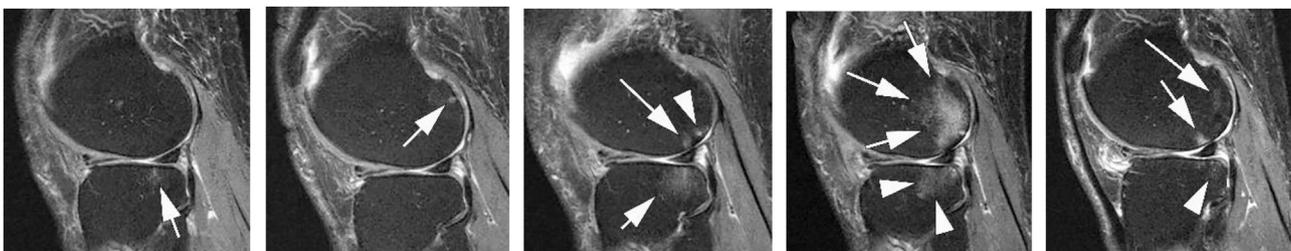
Example longitudinal assessment of bone marrow lesions (BML) in the lateral tibio-femoral compartment. BMLs are fluctuating features of OA that may show decrease in some subregions and increase in others over time. A. Baseline sagittal intermediate-weighted fat-suppressed MRI shows a grade 1 MOAKS BML in the posterior lateral tibia displaying high-signal intensity, comprised of an ill-defined (edema-like) component only (arrow). B. Follow-up MRI one year later shows complete resolution of tibial BML but a dot-like small new BML at the posterior lateral femur (arrow). C. Further follow-up 1-year later shows incidence of a large grade 3 BML at the posterior lateral tibia (short arrow), complete resolution of posterior femoral BML, but new small BMLs at the posterior lateral femur (arrowhead) and central lateral femur (long arrow). D. Three years after baseline, there is a single large grade 3 BML at the posterior lateral femur that reaches into the central subregion of the lateral femur. Tibial BML show a similar size compared to previous visit (arrowheads). E. After four years, the large femoral BML has largely regressed with two remaining small grade 1 BMLs at the posterior (short arrow) and central lateral femur (long arrow). Also, the tibial BML shows decrease in size - now to a small grade 1 lesion (arrowhead).
